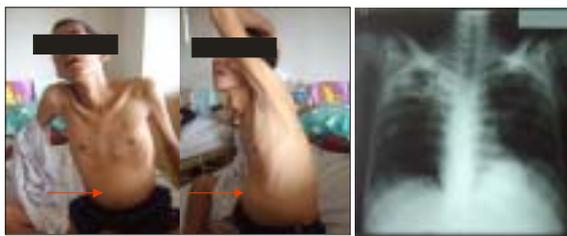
Patient condition with asymmetrical abdomen and his chest X-ray
